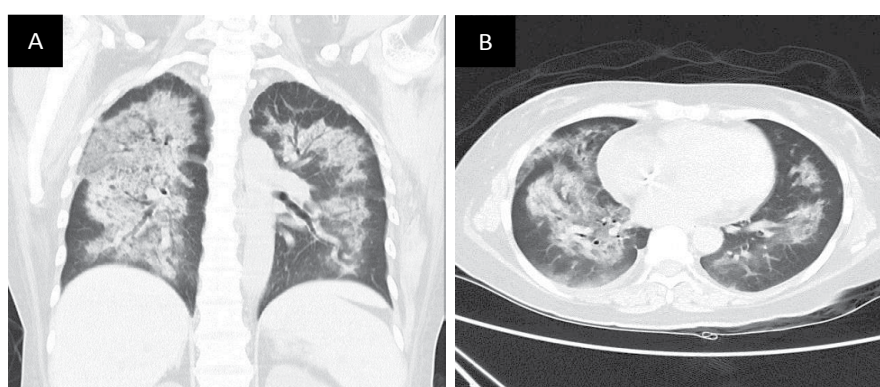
Coronal (A) and axial (B) views of chest CT scan showing diffuse alveolar involvement.
